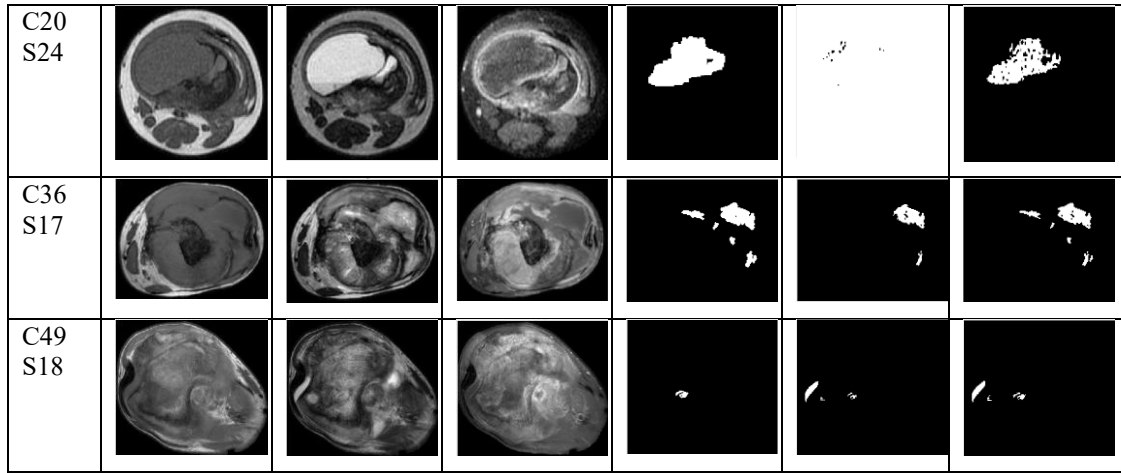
The Result of MRI Image Necrosis Extraction
